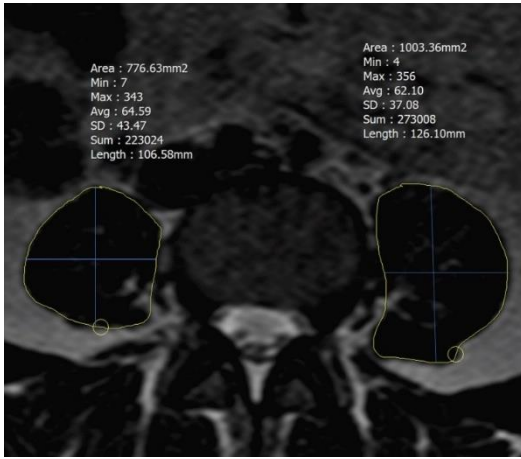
Axial T2-weighted image, psoas muscle area measurements are done with polygonal ROI (yellow) and diameter measurements (anterior-posterior and transverse) are seen (blue).
